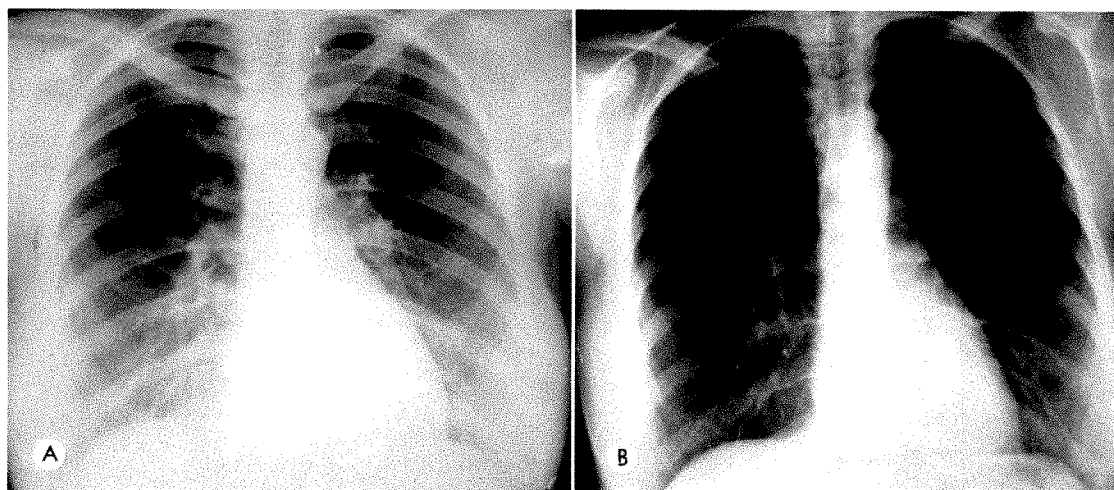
(*A*) Conventional posteroanterior chest roentgenogram. (*B*) High kilovoltage chest roentgenogram using a grid but not the wedge filter, still showing that the apices are overpenetrated.
